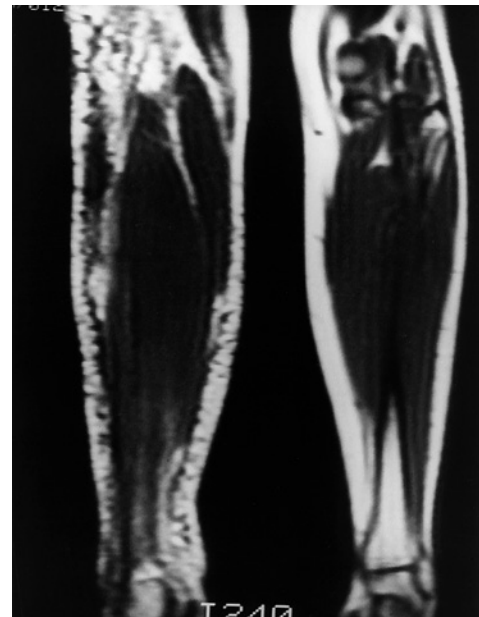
Coronal T1-weighted magnetic resonance image of the calves (repetition time 500, echo time 20) of the patient shown in Fig. 4.7. Multiple small collateral vessels in the subcutaneous fat of the right calf are shown as a spaghetti-like accumulation of dermal venulectases. Note the enlarged lateral accessory vein present along the posterolateral aspect of the right calf.
